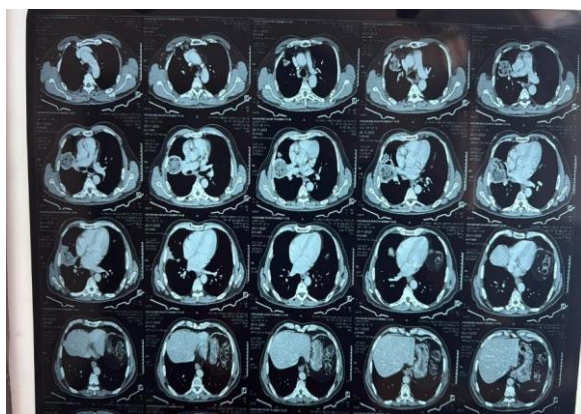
Axial sections of Contrast-Enhanced Computed Tomography (CECT) of the Thorax (recent)
